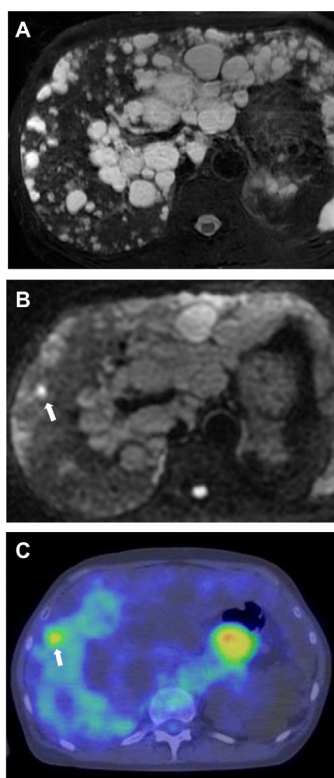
Preoperative magnetic resonance imaging and positron-emission tomography in Case 2. (A) T2-weighted image revealing multiple cysts in the liver. Diffusion-weighted magnetic resonance imaging (B) and positron-emission tomography (C) were able to detect tumor (arrow).
